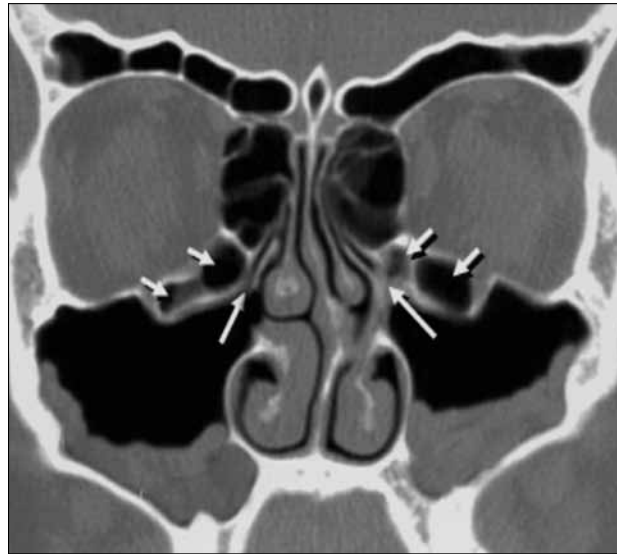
Cranio-facial CT scan, coronal slice - remnant infraorbital cells obstructing the natural maxillary ostium.
